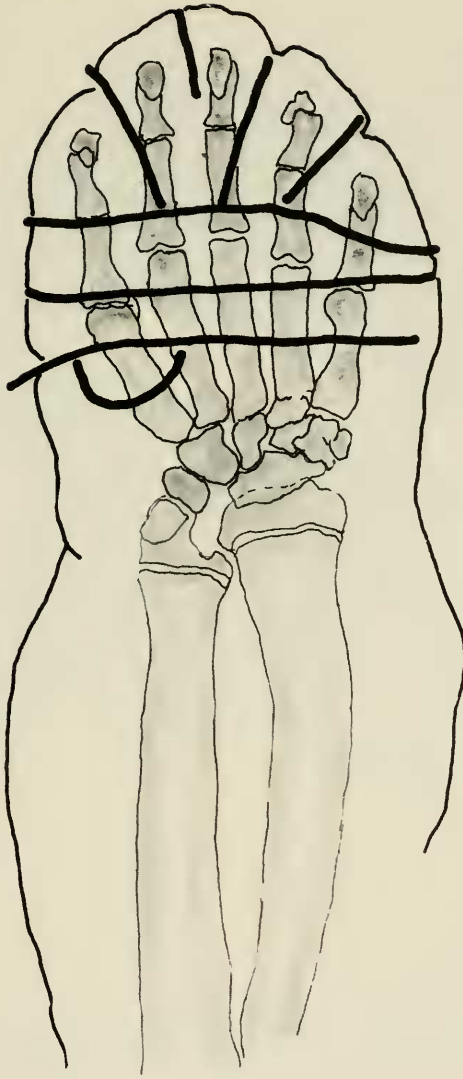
This figure is a direct line copy of an x-ray of the hand and wrist after soft iron wires were placed in the creases of the palmar pad. This was done to show the relationship of these crease lines to the underlying joints. The pad itself lies distal to the most proximal wire (heavy line). From this it is to be noted that the volar pad covers only the distal one-half of the metacarpals plus the phalanges. The main transverse creases are at metacarpal phalangeal joint level. Therefore when walking on this pad the otter does not walk on the flat of the hand as it appears, but rather on the metatarsal heads and the phalanges. This is readily understandable in view of the limited dorsiflexion of the wrist and the great degree of hyperextension of the metacarpal phalangeal joints.
